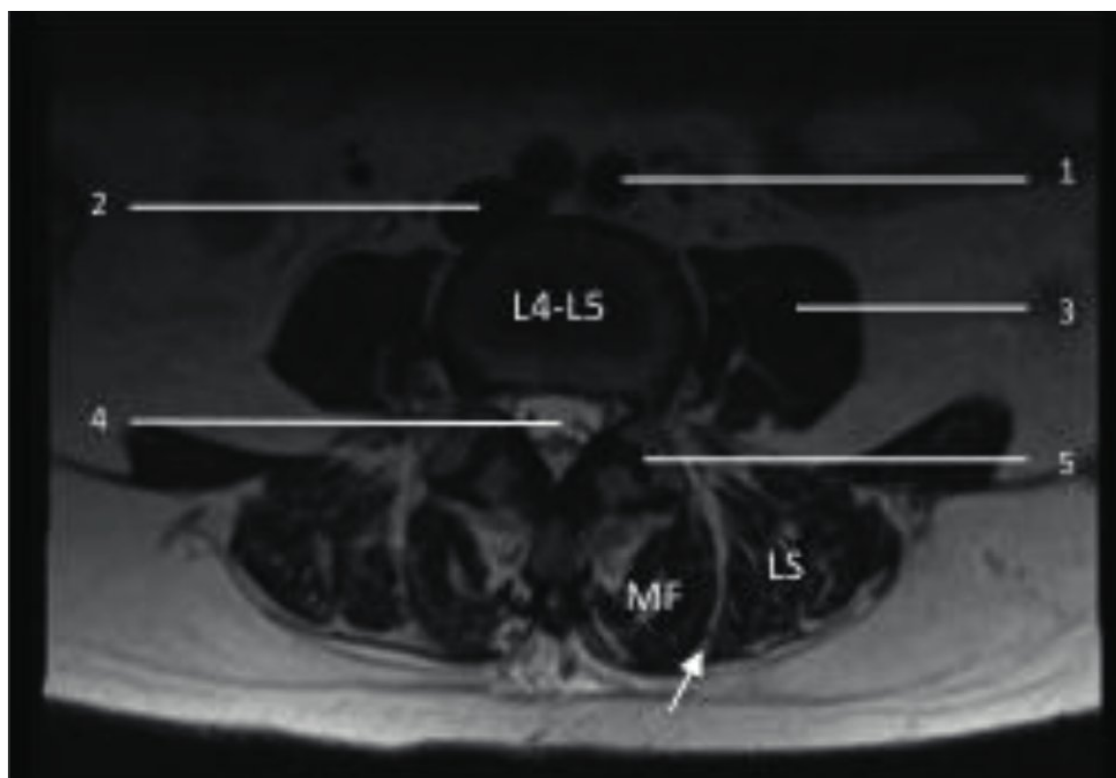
Lumbar spine (magnetic resonance imaging, T2—axial cut L4–L5 disk). 1, left common iliac artery (immediately after bifurcation of the abdominal aorta); 2, inferior vena cava (prior to bifurcation of the left and right common iliac veins); 3, left psoas muscle; 4, spinal canal (cauda equina); 5, facet joint; MF, multifidus muscle; LS, longissimus muscle; arrow, intermuscular Wiltse plane (used in minimally invasive approaches and pedicle screw placement).
